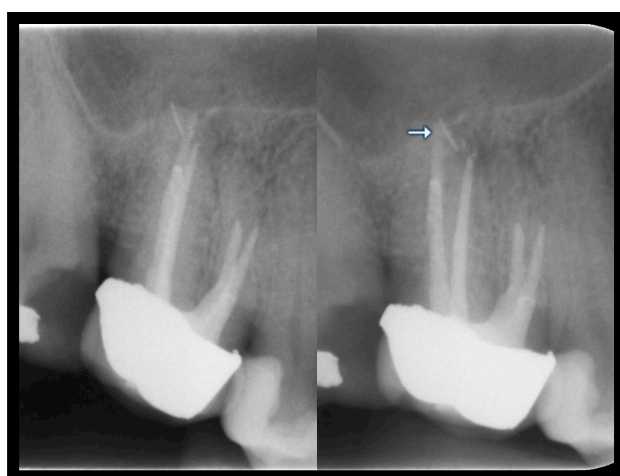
Pretreatment radiographs. Right is distoangulated, locating fragment to the DB apex
